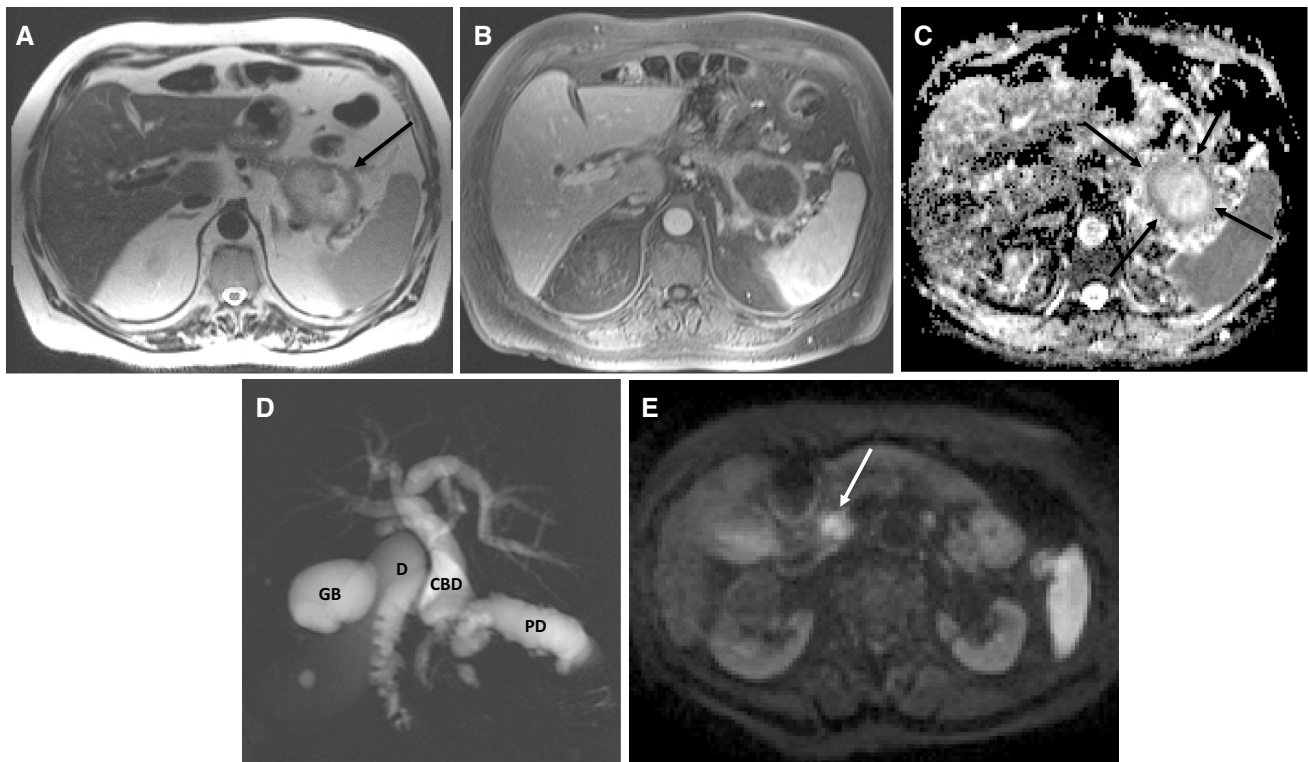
MRI of pancreatic adenocarcinoma. The axial T2-weighted image a shows a large necrotic pancreatic tail mass (arrow). The corresponding axial fat-suppressed T1-weighted postcontrast image b confirms the lack of enhancement in the necrotic center with a ring of peripheral enhancing tissue. The ADC map image c shows the hypointense, diffusion-restricting peripheral viable tumor (arrows).
